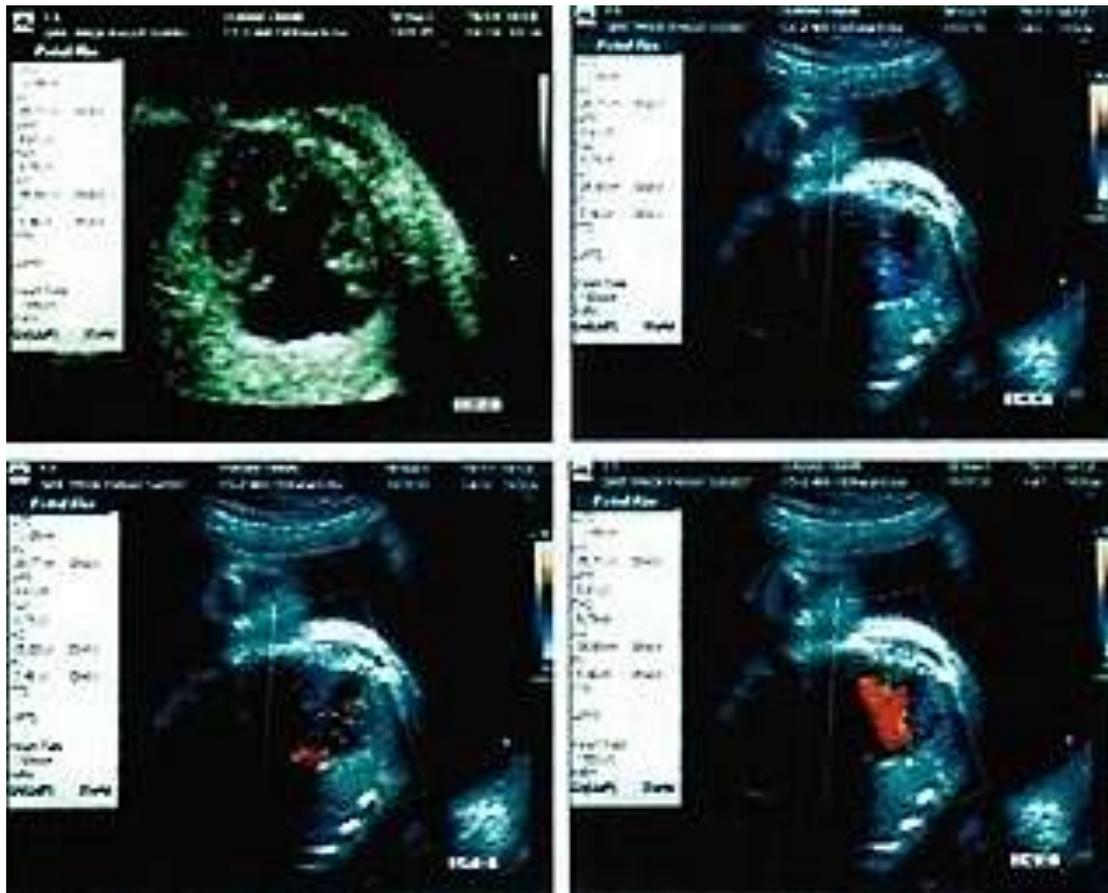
Ultrasound examination of the fetal cord using two-dimensional ultrasound (2D) and 2D power Doppler
